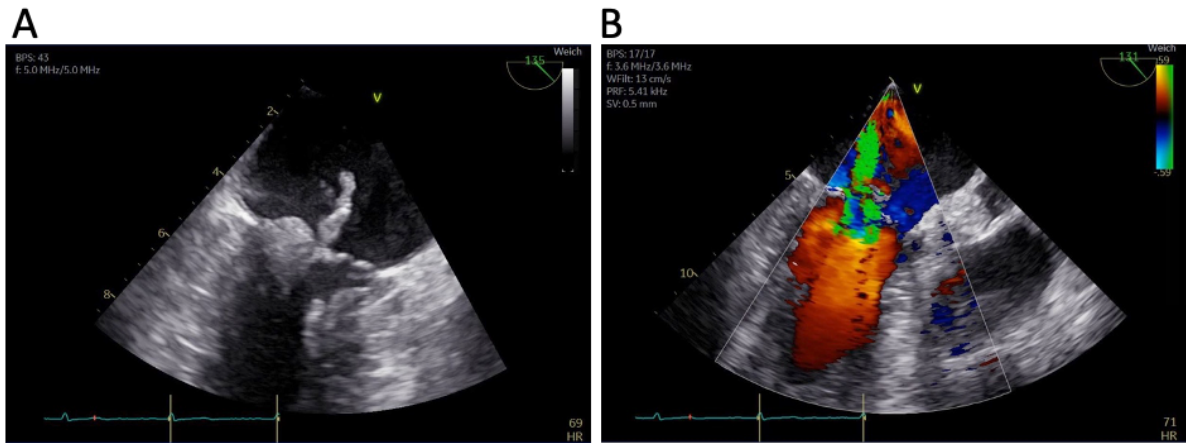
Trans-oesophageal echocardiography showing vegetation on posterior and anterior mitral leaflet (A) with accompanying severe mitral valve insufficiency (B)
